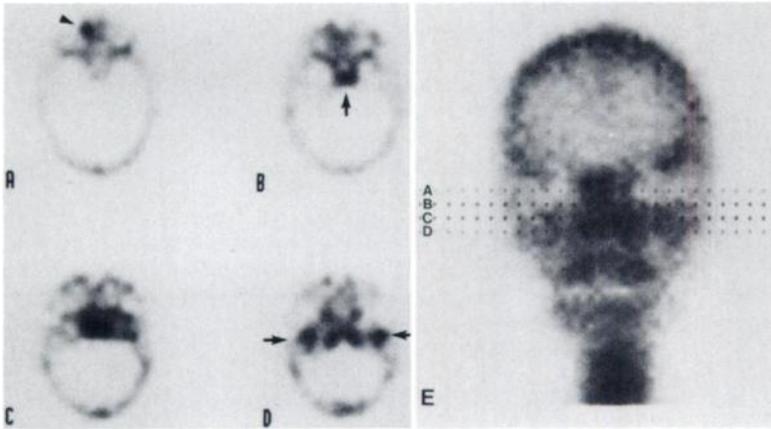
A-E: Transaxial SPECT images (A-D) of patient with sinusitis. Slice A shows increased activity in right ethmoid region (arrow head) flanked by orbits. Slice B shows lower portion of orbits and increased activity in midline in sphenoid sinus (arrow). Slice C shows region of maxillary sinuses and inferior portion of sphenoid sinus, and D is at level of temporomandibular joints (arrows). Planar image E is provided for orientation to level of these slices.
